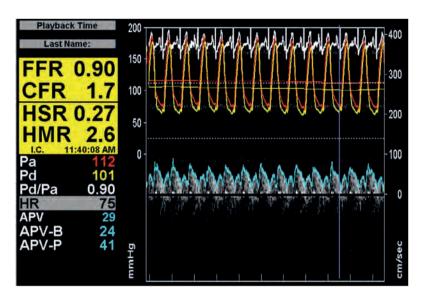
Combined pressure and Doppler flow velocity recordings to assess the coronary flow velocity reserve (CFVR) and the hyperaemic microvascular resistance index (HMR) using the ComboMap* system (Volcano Corp., San Diego, CA, USA).
